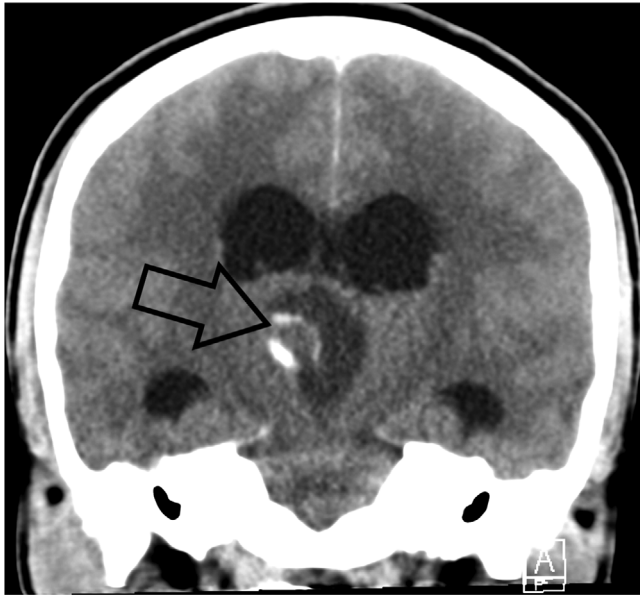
Coronal computed tomography (CT) of brain depicts 2.5 cm right intraventricular third ventricle mass (arrow) with mixed density consistent with ependymoma versus dermoid tumor occluding the cerebral aqueduct resulting in third and lateral ventricle hydrocephalus
